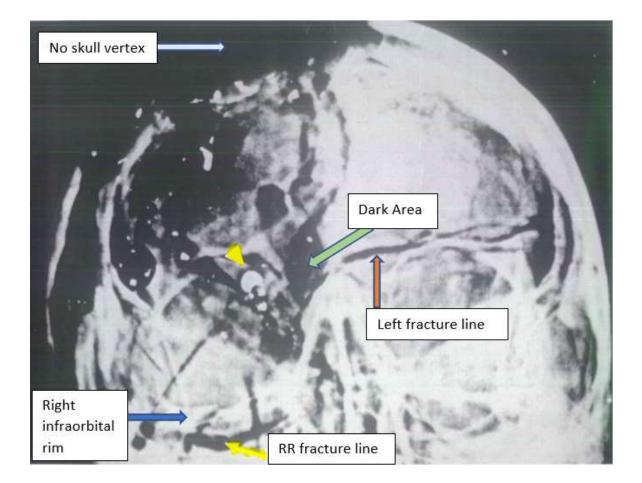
This is the HSCA-enhanced, AP skull X-ray. RR himself placed the lower yellow arrow to identify the correlate of his transverse fracture (shown in Figure 1). The upper yellow arrow (placed by RR) identifies the 6.5 mm object, which RR claims was deposited on the rear of the skull as a frontal bullet *exited*. See the text for discussion of the Dark Area. I interpret the "Left fracture line" as identical to the one (orange arrow) in Figure 1.
